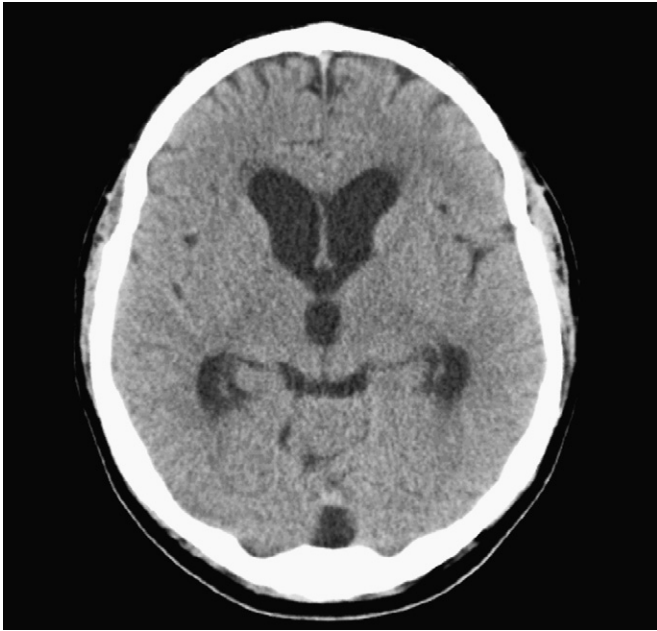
CT Brain showing communicating hydrocephalus.
